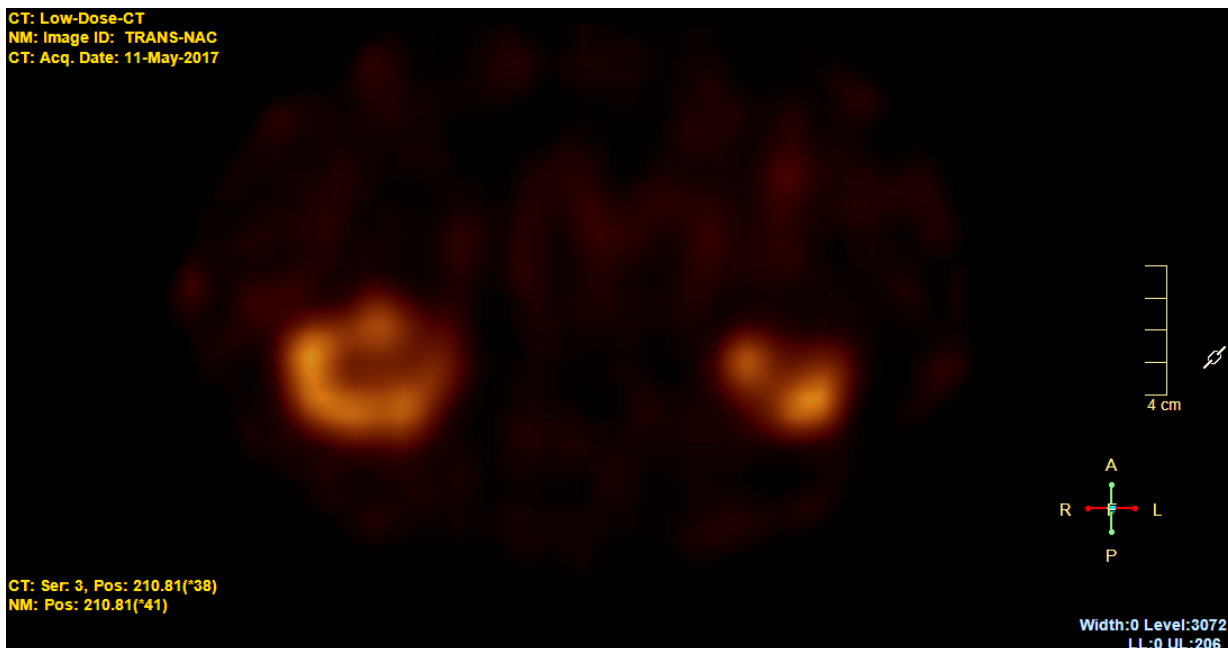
SPECT image without CTAC.
